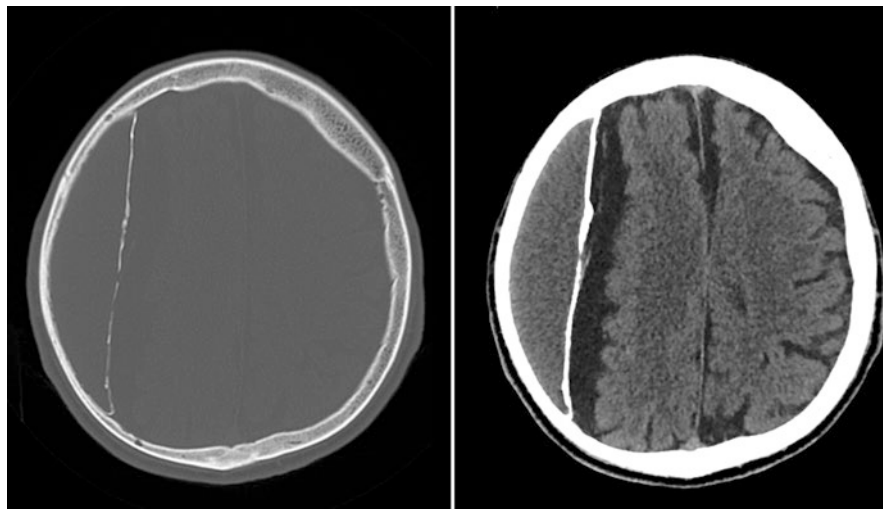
CT image of a calcified/ossified cSDH, which requires craniotomy if the patient is symptomatic
